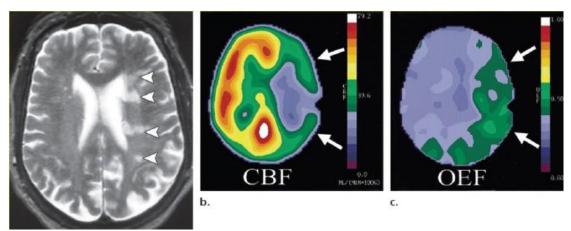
(a) Axial T2-weighted spin-echo MR image through the corona radiata shows several white matter infarcts (arrowheads) parallel to the long axis of the lateral ventricle. (b, c) Axial PET images show reduced cerebral blood flow (CBF) (arrows in b) and an increased oxygen extraction fraction (OEF) (arrows in c) in the hemisphere ipsilateral to the occluded carotid artery. (Mangla, et al., 2011)
